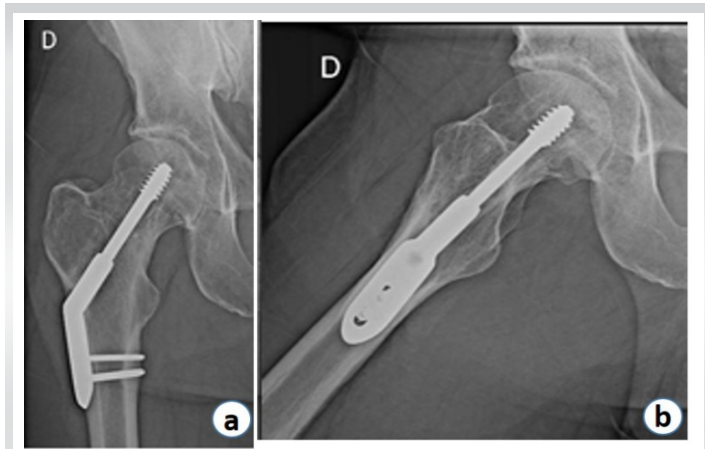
Standard X-rays at 12-month post-operative. Acquired bone union in the 60-year-old patient. (a) Frontal, (b) Profile
